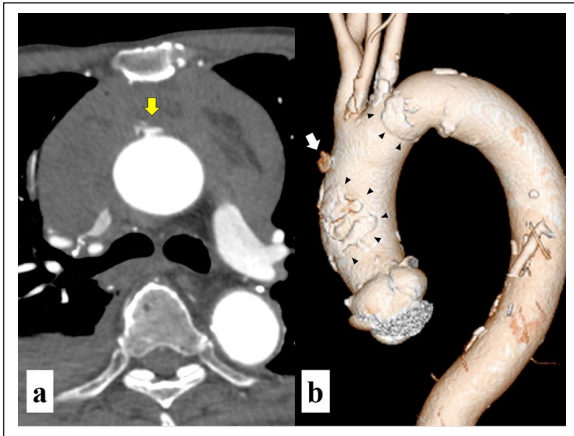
(a) CT reveals the extravasation of contrast media from the ascending aorta (yellow arrow) that created a large hematoma in the anterior mediastinum and right hemithorax. (b) The bleeding point (white arrow), located at the distal ascending aorta, is surrounded by multiple calcium plaques (black arrowheads).
